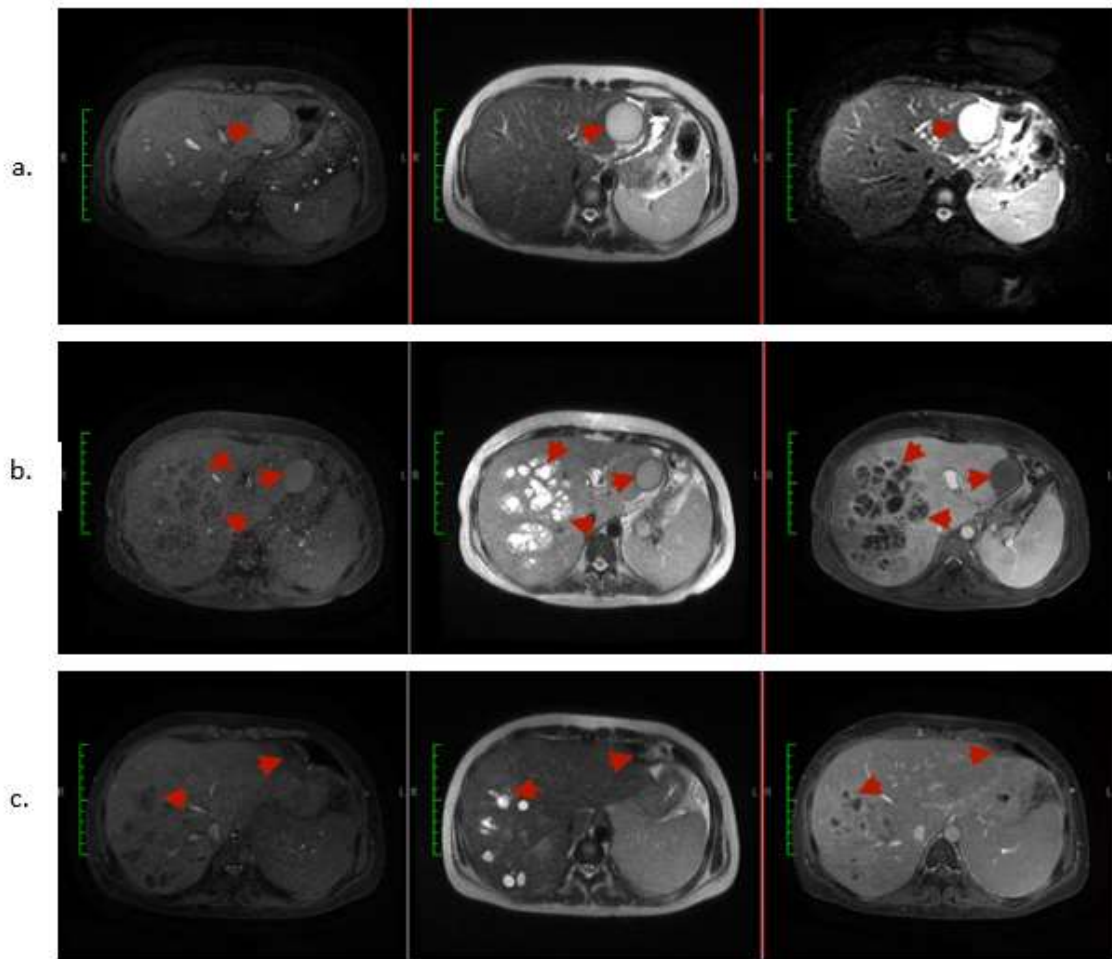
(a) Liver abscess in peripheral segment II, III of the liver lobe (MRCP November 2022); (b) Liver abscesses in segments V, VI, VII, and VIII of the liver and edematous pancreatitis (MRCP evaluation in February 2023); (c) Compared to the previous MRI, the abscess impression was reduced), simple cyst in segments II and III of the liver lobe (MRCP evaluation in March 2023).
